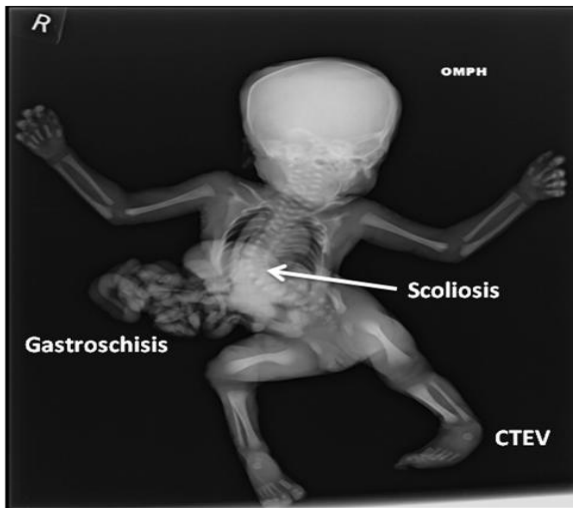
X-ray showing Right sided Gastroschisis, CTEV & Scoliosis.
